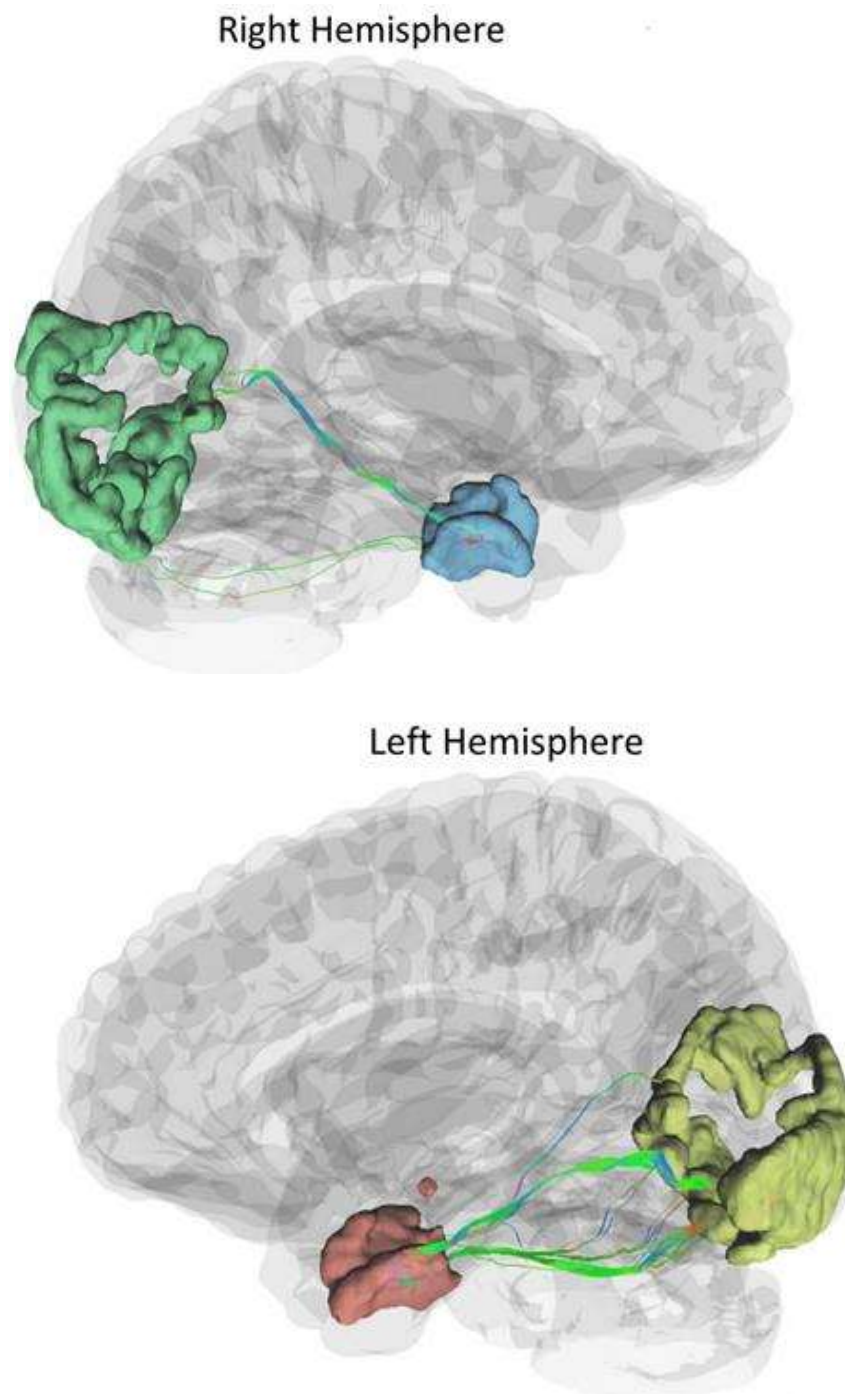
Anatomical connectivity (neural tracts) between the entorhinal cortex and visual cortex (area V2), obtained from MRI-tractography analysis of the 7 Tesla diffusion MRI scan. (Cognitively normal, female, 27 years)
